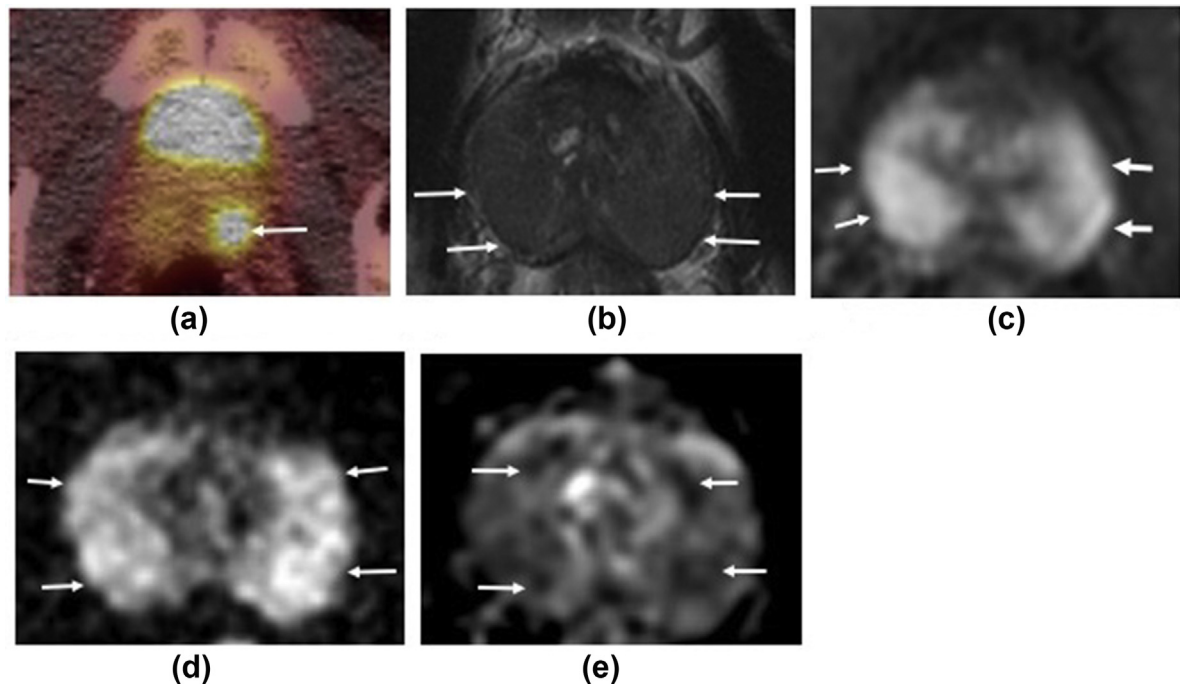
A 32-year-old man with flu-like myalgias and headache in the setting of VGKC autoantibodies. PET-CT was performed to assess for paraneoplastic syndrome and demonstrated asymmetric intense FDG uptake in the left prostate gland (a, arrow). mpMRI, 9 months later, demonstrated diffuse abnormal T2 hypointensity (b, arrows) involving nearly the entirety of the bilateral peripheral zones with associated abnormal enhancement (c, arrows), restricted diffusion (d, arrows) and signal loss on ADC maps (e, arrows). These findings were most compatible with IgG4 related prostatitis (prostate-specific antigen 0.8 ng/ml).
